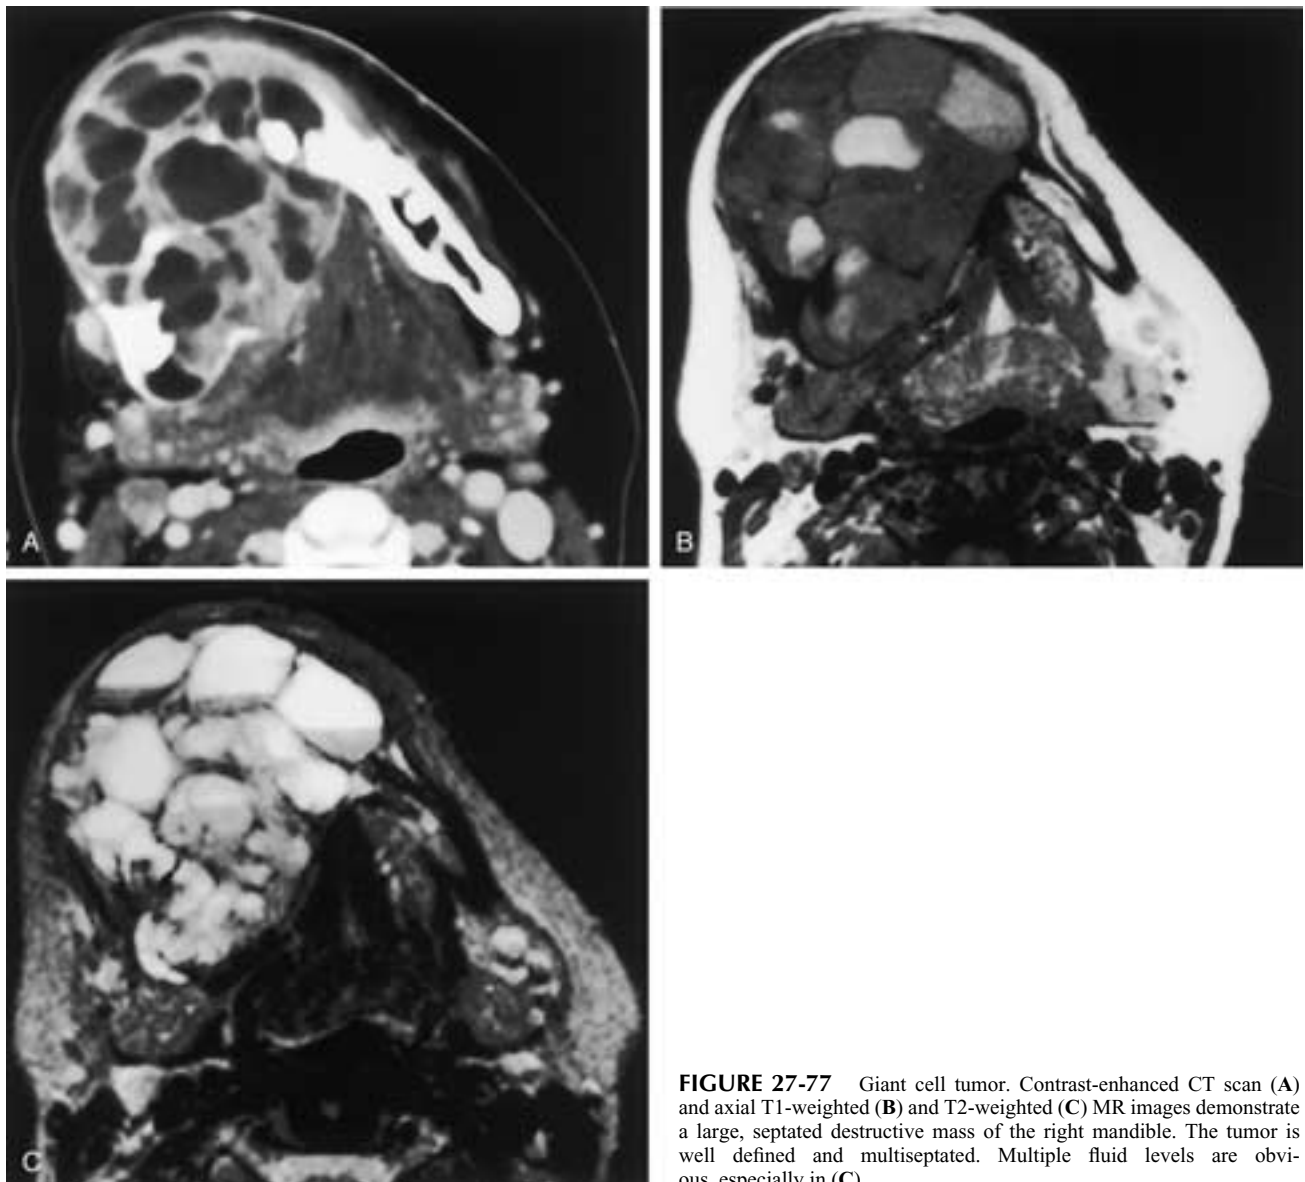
Giant cell tumor. Contrast-enhanced CT scan (A) and axial T1-weighted (B) and T2-weighted (C) MR images demonstrate a large, septated destructive mass of the right mandible. The tumor is well defined and multiseptated. Multiple fluid levels are obvious, especially in (C).
